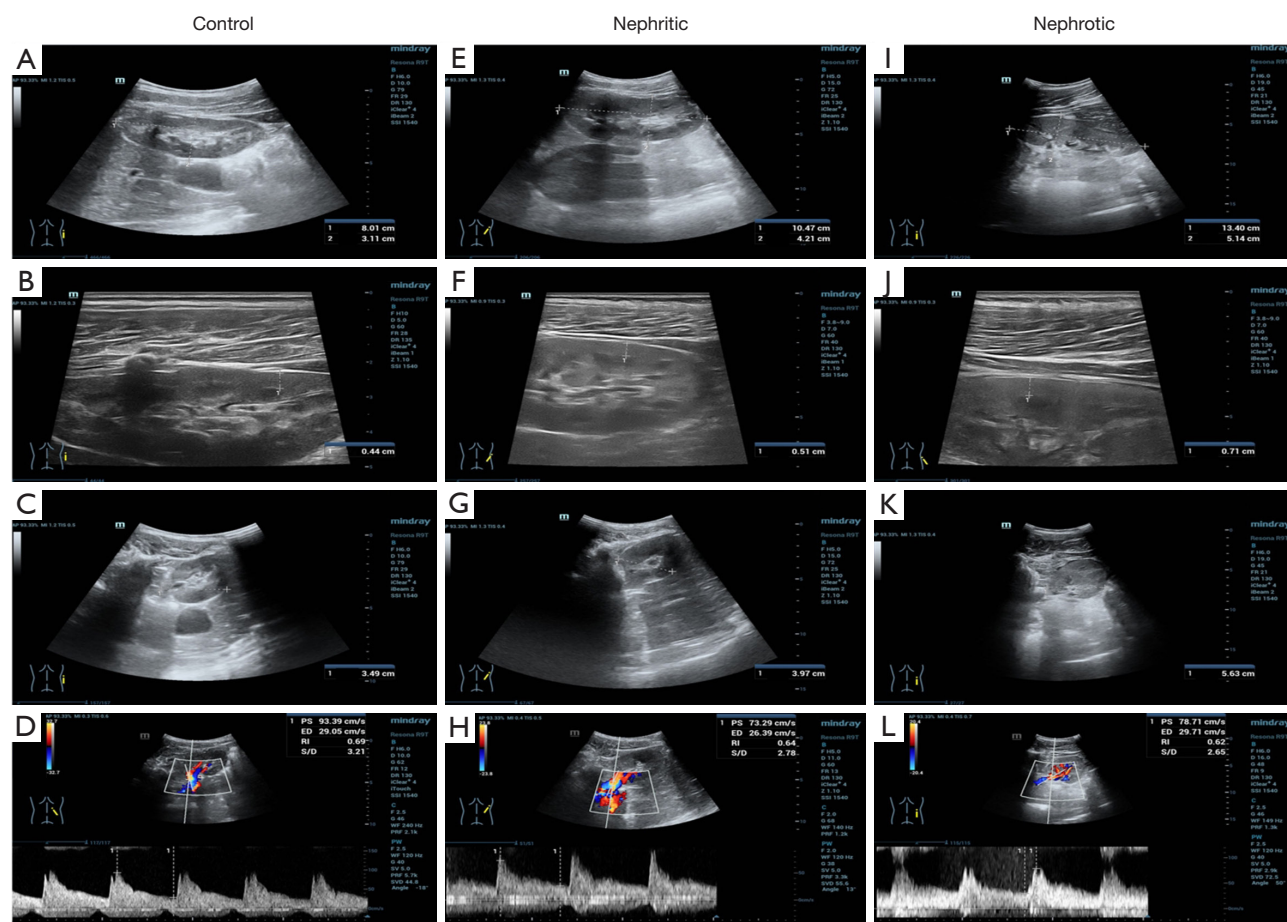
Renal ultrasound examinations were performed on participants. Control: 6 years old, female, the right kidney volume (A,C), cortical thickness (B), and renal artery hemodynamic parameters (D). Nephritic: 9 years old, male, the right kidney volume (E,G), cortical thickness (F), and renal artery hemodynamic parameters (H). Nephrotic: 15 years old, male, the right kidney volume (I,K), cortical thickness (J), and renal artery hemodynamic parameters (L). PS, peak systolic velocity; ED, end-diastolic velocity; RI, resistance index; S/D, peak systolic velocity/end-diastolic velocity.
